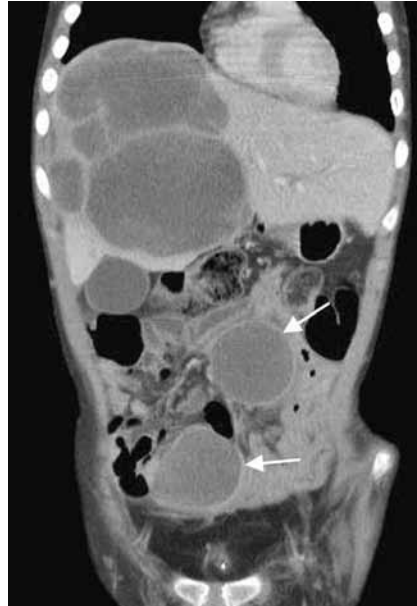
Interval computed tomography during second chemotherapy shows a significant enlargement of the liver lesions and the presence of two similar intra-peritoneal lesions (arrows).
